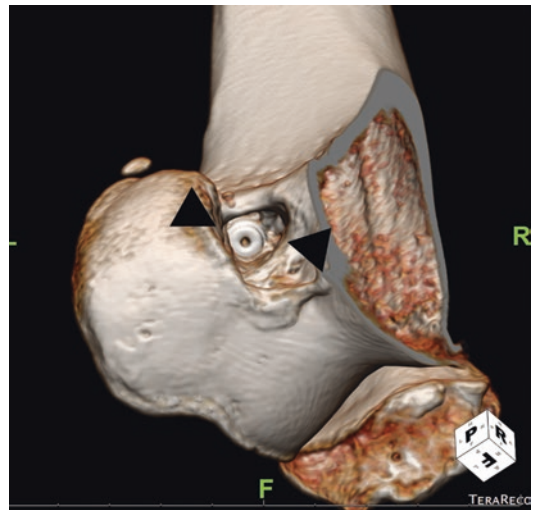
Utility of 3D CT in the evaluation of the ACL graft tunnel. A 3D reconstructed CT image with medial femoral condyle subtraction demonstrates the aperture of the femoral tunnel (arrowheads), which appears widened, with gapping between the tunnel wall and the femoral interference screw
